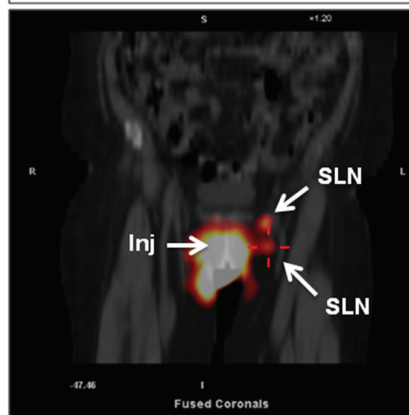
A FIGO stage II vulvar cancer with hot SLNs on SPECT/CT not seen on planar imaging. A. Planar imaging showed no SLN. B. SPECT/low-dose CT revealed 2 hot left inguinal femoral SLNs (white arrows), which were invaded by tumour with macro-metastases > 2 mm at the final pathology. SLN: sentinel lymph node. Inj: injection site.
